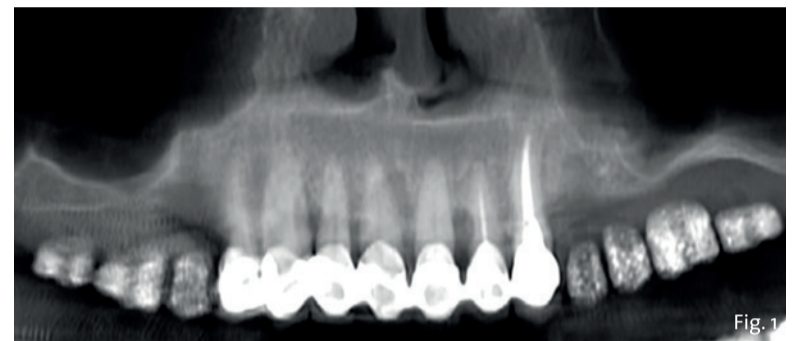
Pre-operative CBCT showing atrophy at the Q1 and Q2 quadrants.
